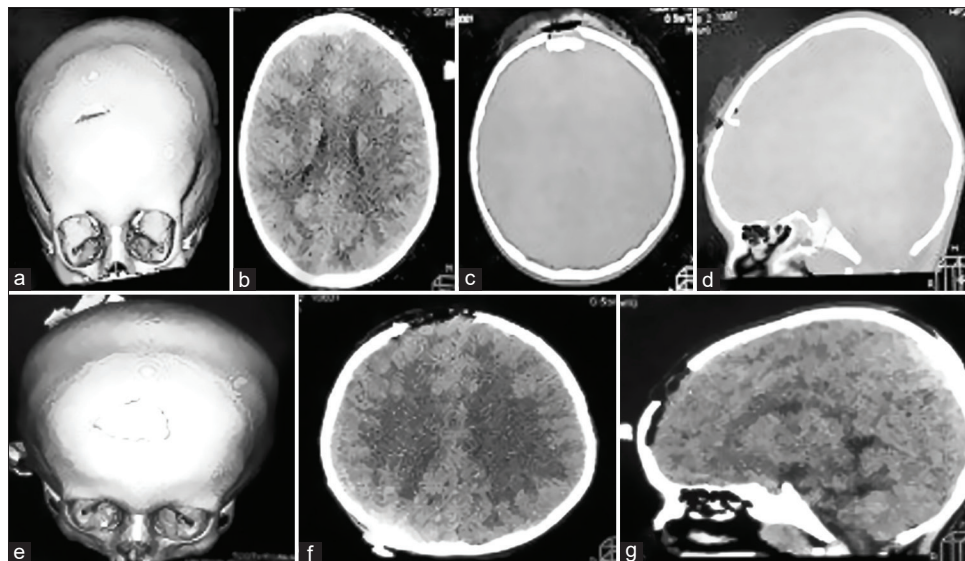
Cranial computed tomography scan showed right frontal open full-thickness depressed skull fracture extending to the midline with an underlying fracture hematoma, pneumocephalus associated with superior sagittal sinus injury. (a) three-dimensional skull reconstruction showed sharp right frontal bone depression fracture (b) axial brain section showed midline frontal extradural hematoma (c) axial bone section showed the depressed bone segment with overlying subgaleal hematoma and (d) midline sagittal bone section showed the depressed bone segment with aerocele. (e) postoperative three-dimensional skull computed tomography reconstruction showed the craniectomy defect. (f) Postoperative axial computed tomography brain section showed midline bone defect due to the removal of the depressed bone segment with evacuation of the frontal extradural hematoma (g) postoperative midline sagittal brain section computed tomography scan showed no residual hematoma or bone spikes
